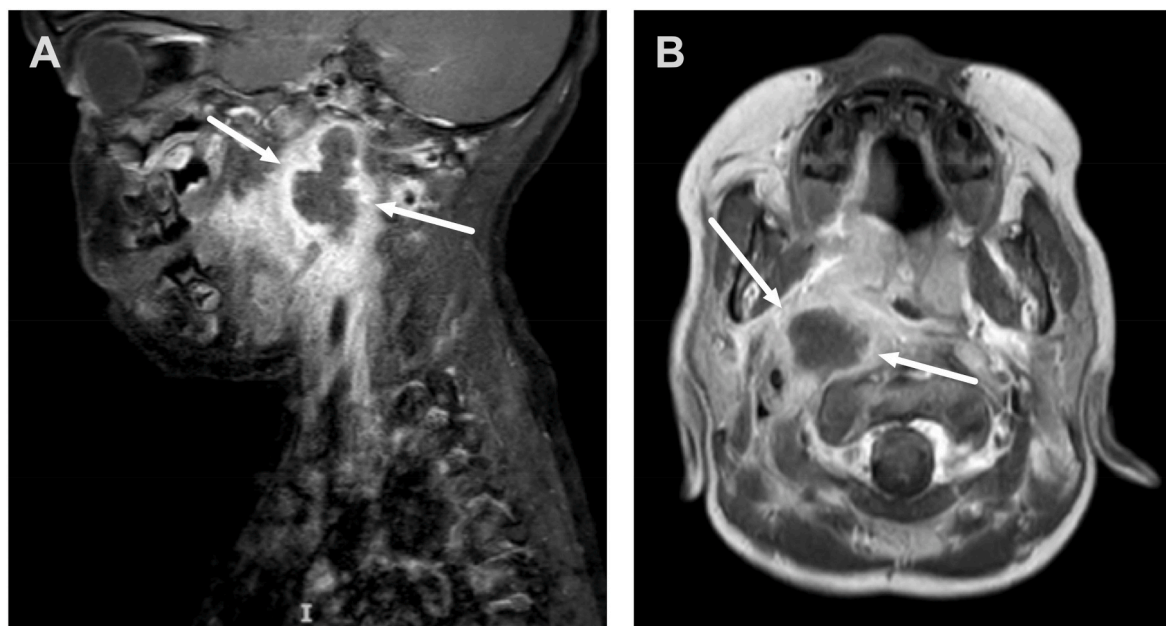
A retropharyngeal abscess in a 4-year-old boy. Sagittal (A) and axial (B) gadolinium-enhanced T1-weighted MR images demonstrate a large (about 2 x 2.5 x 4 cm), ring-enhancing lesion with a non-enhancing center in the retropharyngeal space, consistent with an abscess. This abscess was located medial to great vessels, and was thus successfully incised and drained intraorally after tonsillectomy.
